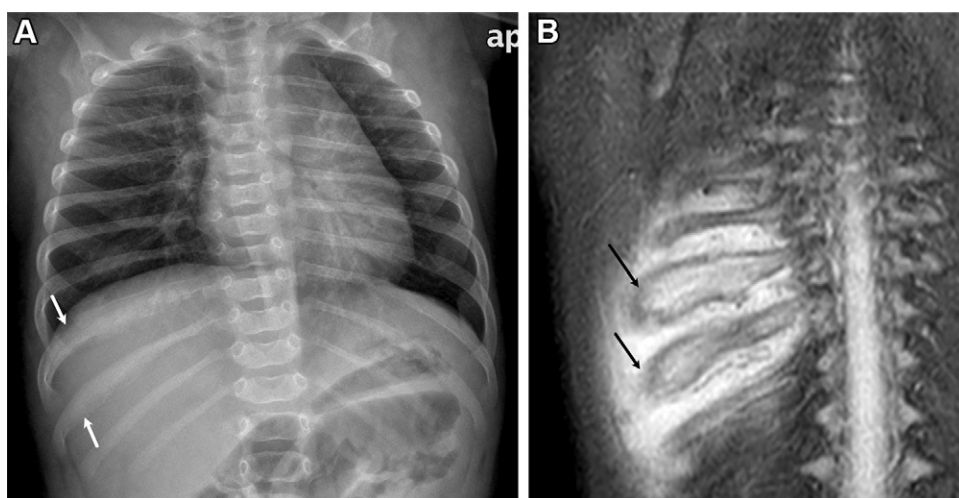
Caffey disease in a 3-month-old boy. (A) Frontal chest radiograph shows cortical hyperostosis of the right ninth and tenth ribs (arrows). (B) Coronal fat-suppressed T2-weighted MR image shows cortical expansion and bone marrow edema of the ribs associated with adjacent intercostal soft-tissue edema (arrows). (Figure courtesy of Talaat Youssef, PhD, FRCR, FFRCSI, Sidea Medicine, Doha, Qatar.)
